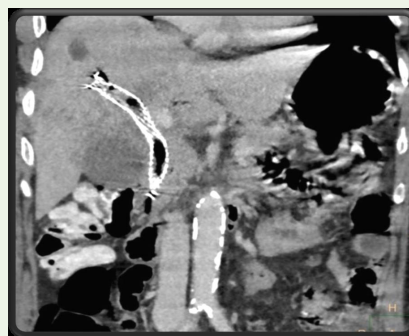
Coronal CT scan showing stent in situ with cholangitic abscess.
